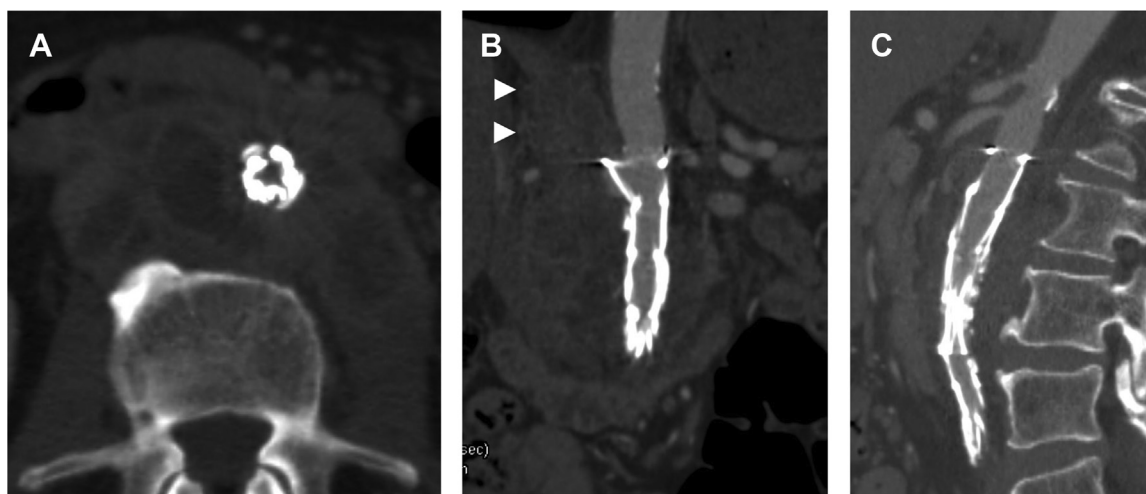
Contrast-enhanced computed tomography (CT) images of abdominal aorta of a patient with *Mycobacterium bovis* infection. A, Significant abscess formation was visible 3 months after endovascular aneurysm repair (EVAR). B, Coronal CT reconstruction image at 3 months after EVAR. The stent graft was deployed just below the renal arteries. The abscess around the aorta extended to the level of the origin of the superior mesenteric artery (arrowhead). C, Sagittal CT reconstruction image at 3 months after EVAR.
